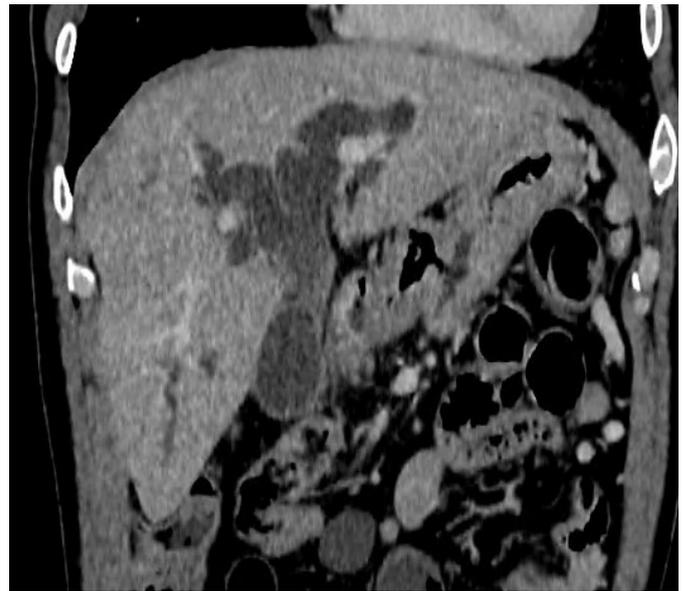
Pre operative CT scan in coronal section, showing significant dilatation of the intra and extra hepatic bile ducts
